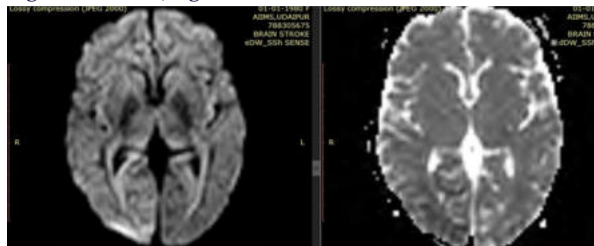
and 3B, Figure 4A and 4BFigure 3A:-DWI SequenceFigure 3B:-ADC Sequence
